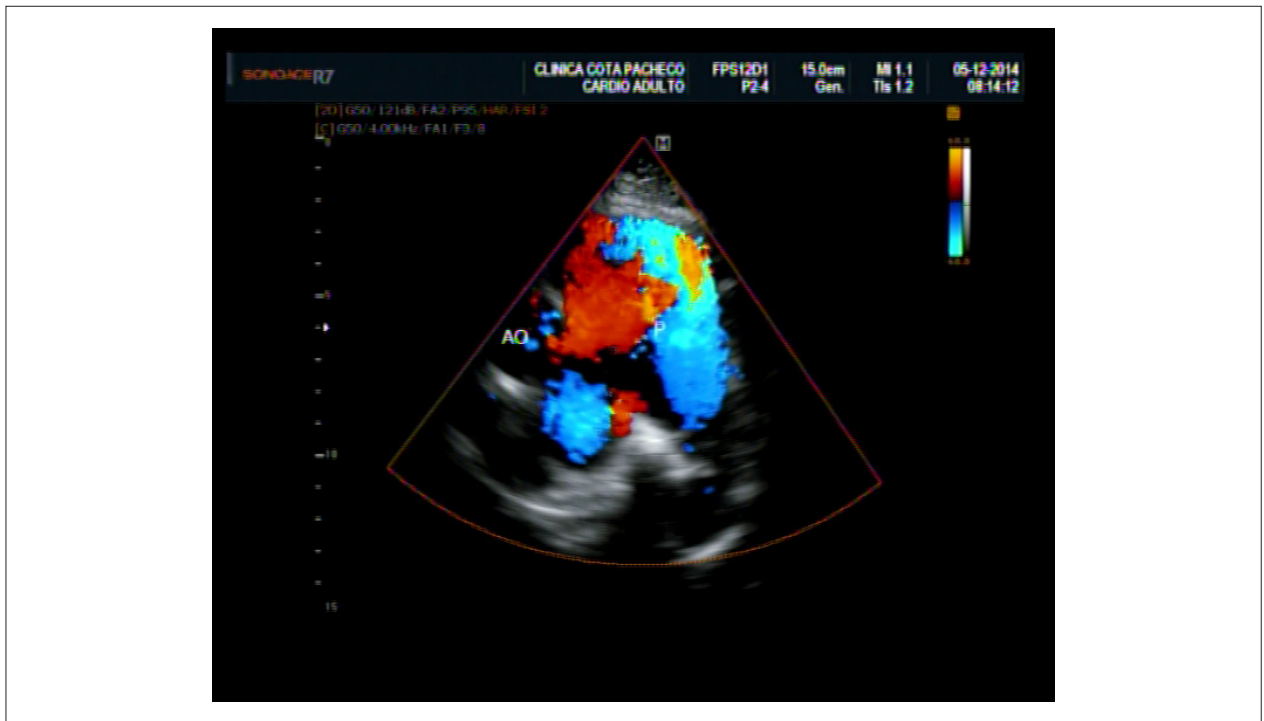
Echocardiography with color flow in the pulmonary artery. AO (Aorta); P (Pulmonary).
